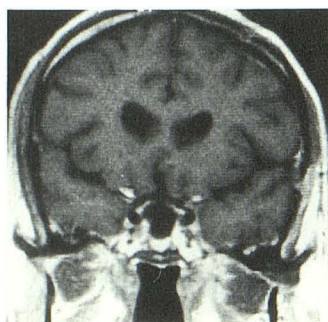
Coronal contrast-enhanced MR image 11 months after onset of treatment shows only minor signal anomalies over the left frontal convexity.
